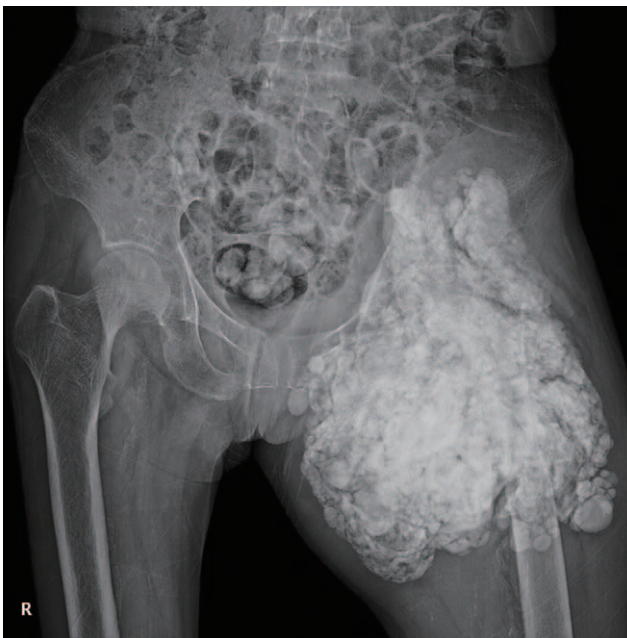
Preoperative plain radiographs of the femoral neck fracture with tumoral calcinosis. The presence of a multiple calcified mass was observed around the left hip joint. The femur neck fracture is not presented clearly because of calcific deposits.
